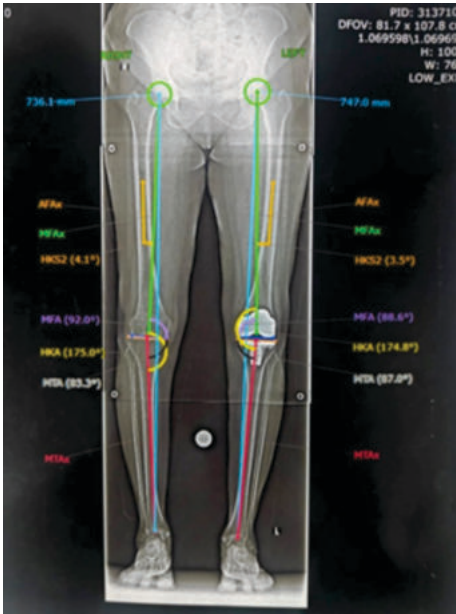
Post-operative Full-length X-ray (standing scanogram)
